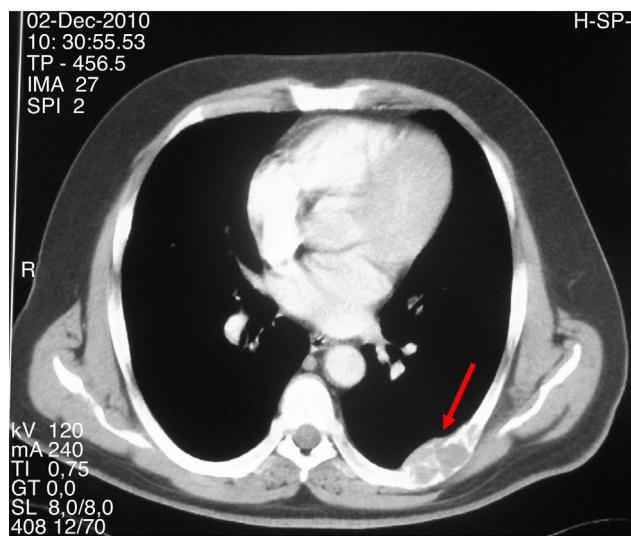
CT scan showing an expansive lytic lesion with lobulated outline and cortical thinning in the seventh left costal arch.
